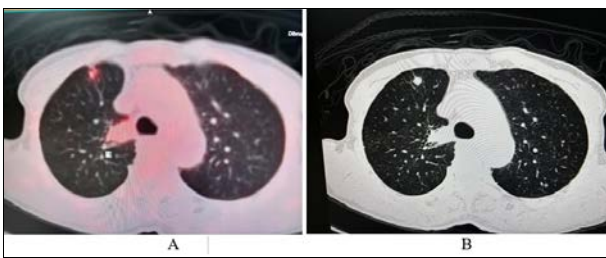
a, b: Fibronodular opacity on right upper lobe anterior lobe showing FDG avidity in a known case of colorectal carcinoma whose biopsy was planned later on and showed biopsy positive for metastatic adenocarcinoma.
